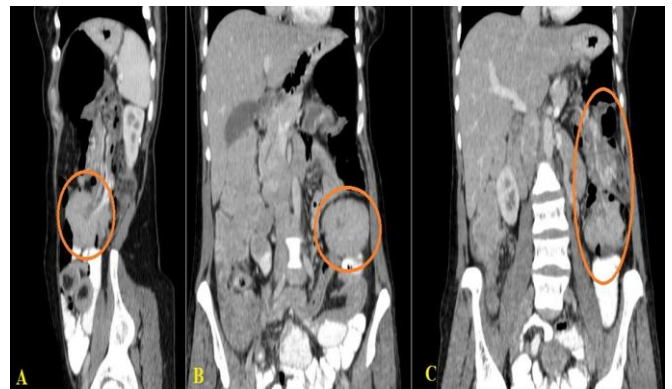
An abdominal computed tomography (CT) scan showing (A); The longitudinal axis representing intussusceptions (Orange circle line) and linear-enhancing structures within mesenteric fat in mesenteric blood vessels (Yellow arrow). (B); The longitudinal axis shows an extended and well-defined mass of fluid density at the tip of intussusception in the descending colon, as well as curvilinear calcification on the cystic lesion wall (Yellow arrow). (C); The longitudinal axis representing a gas-fluid level in dilated proximal loops is indicative of a small intestinal obstruction (Yellow arrow).
